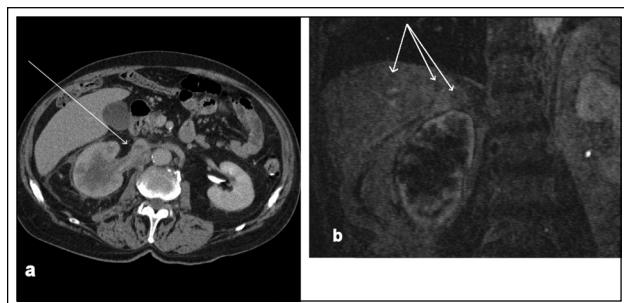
(a) Computed tomography scan of renal mass and vena caval extension (arrow). (b) Magnetic Resonance Imaging demonstrating multiple hepatic nodules (arrows) in addition to the renal mass.
